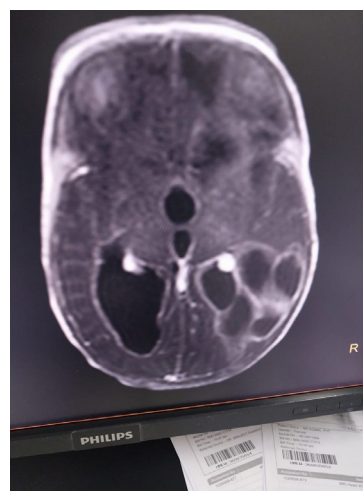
MRI Images showing axial section showing multiple cystic lesions in the brain, likely within the parietal and occipital lobes
